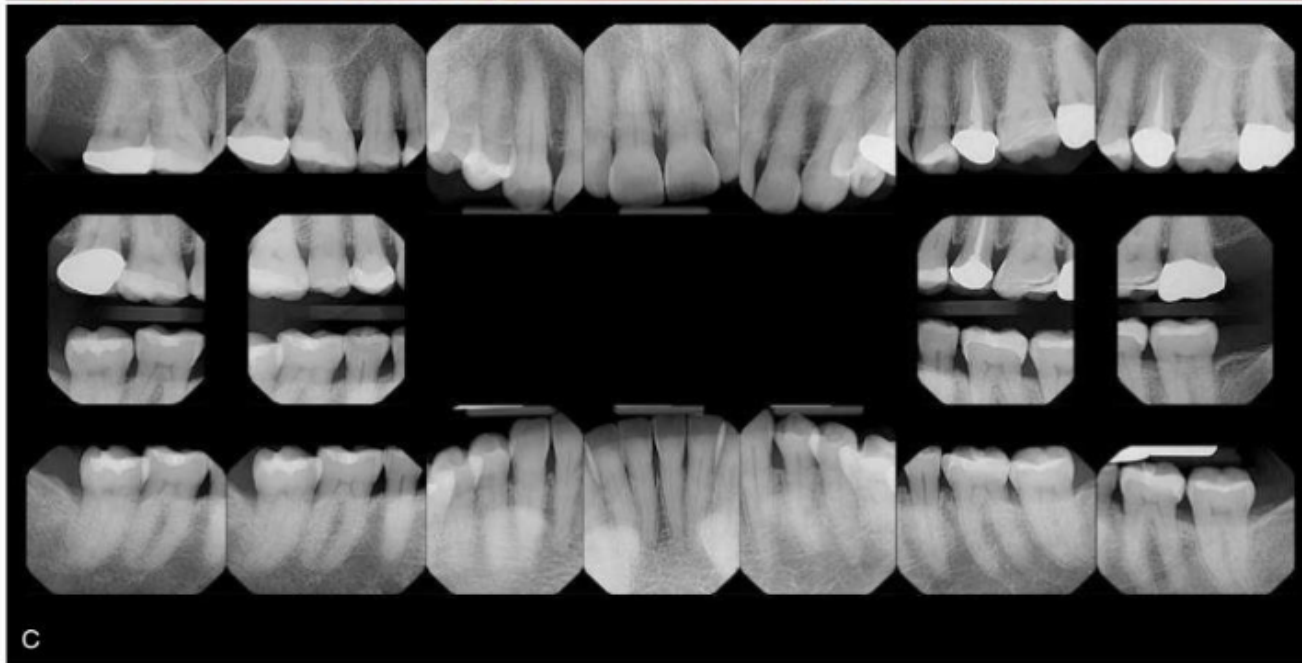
Generalized stage I, grade B periodontitis in a healthy, nonsmoking 67-year-old female. Minimal clinical biofilm and gingival inflammation (A and B) and radiographic bone loss (C). Overall prognosis is favorable. (Copyright Jonathan H. Do, DDS. All rights reserved.)
